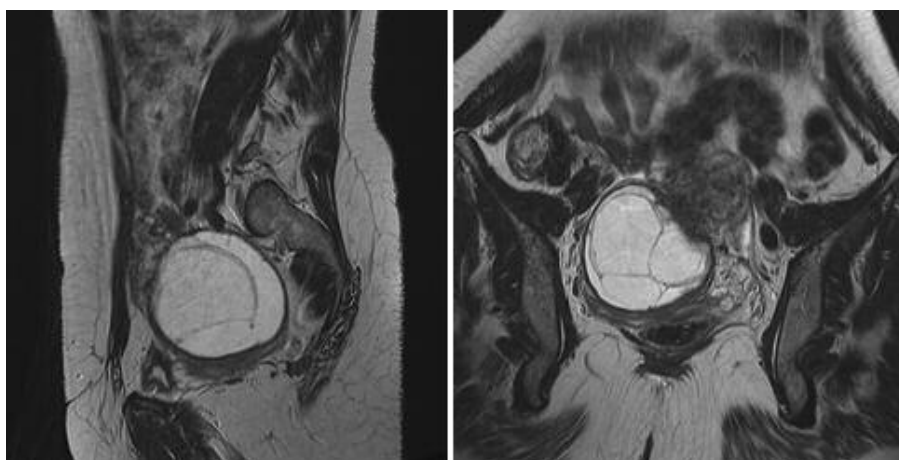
Preoperative sagittal and coronal MRI cuts showing an 8cm mass lateral to the right vaginal wall.
